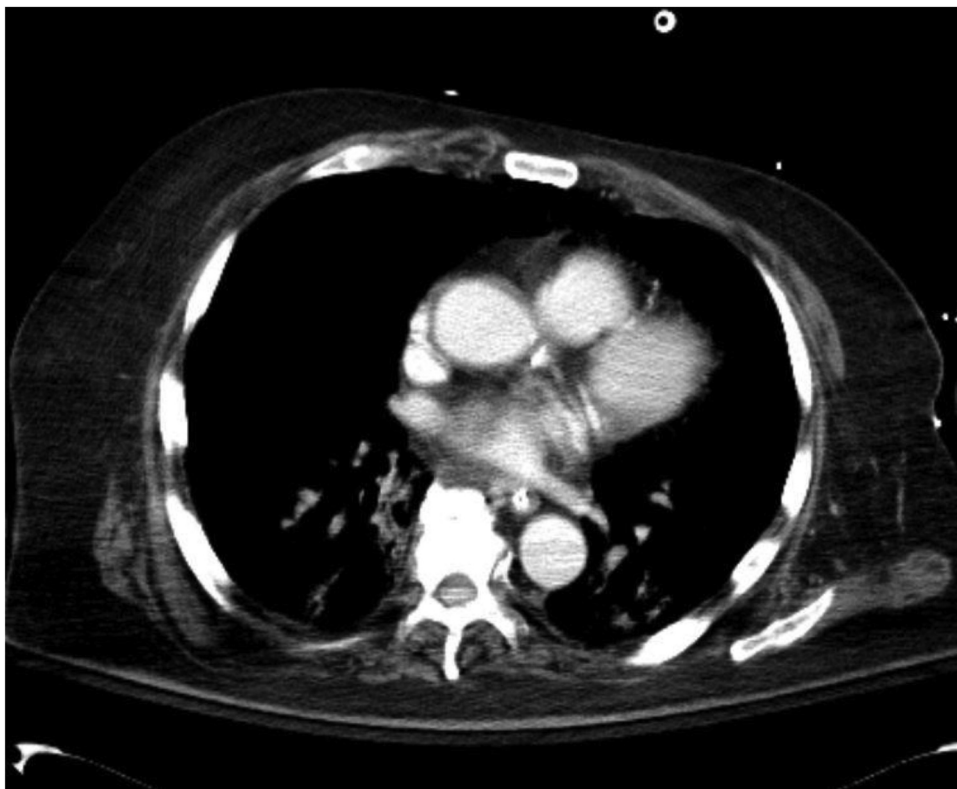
A CT abdomen with contrast demonstrating scant partial pneumomediastinum captured in an intubated patient with COVID-19.
